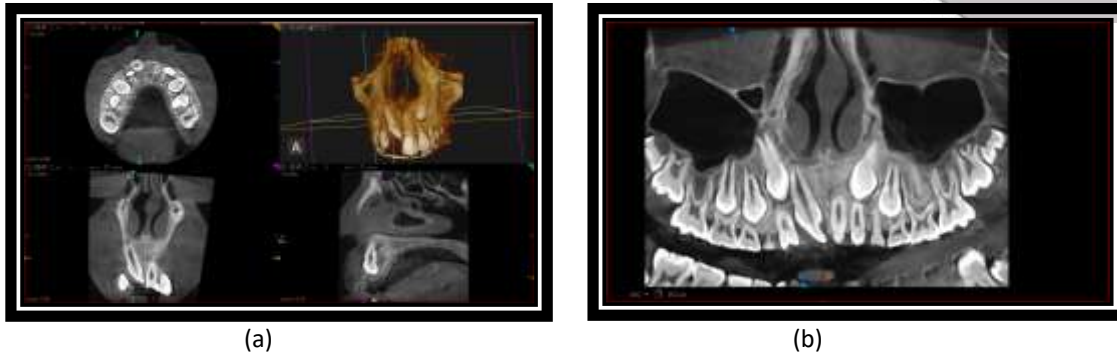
(a) (b) CBCT scan images
